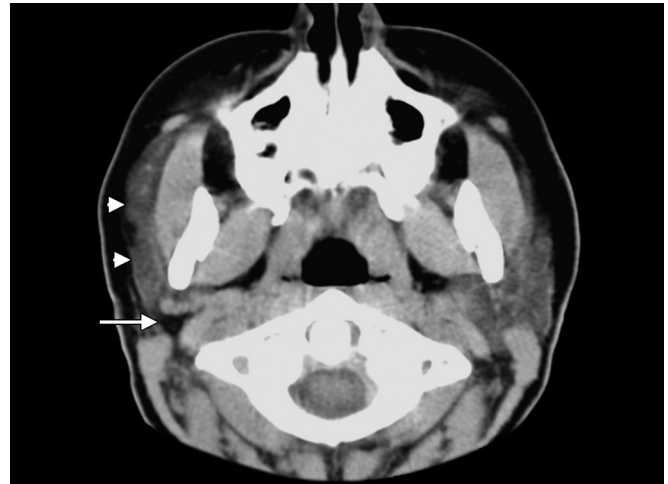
Axial contrast-enhanced CT image shows absence of the right parotid gland in the normal location (arrow), with accessory parotid along the course of the right parotid duct (arrowheads).
